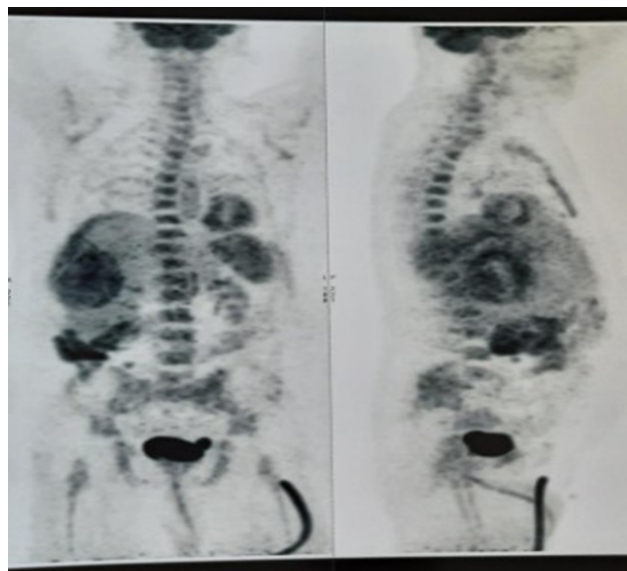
Whole body PET CT scan
